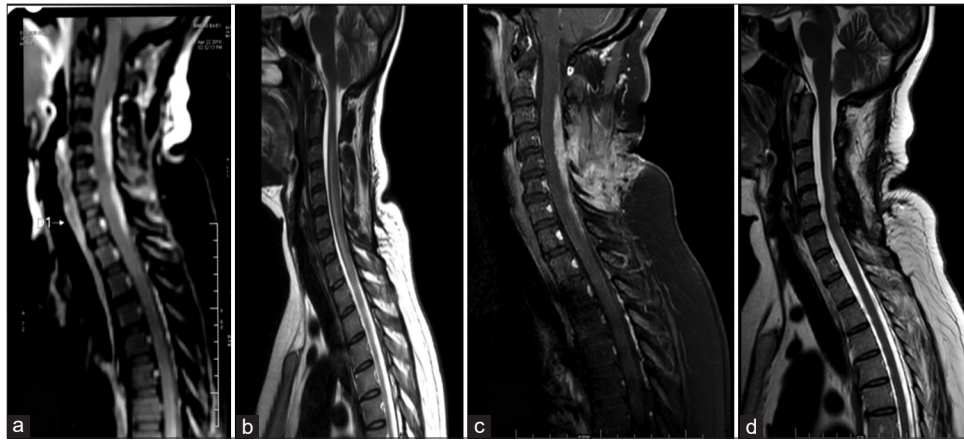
(a) Magnetic resonance imaging (MRI) at presentation; (b) MRI after 1 week of steroid therapy; (c) MRI post-biopsy; (d) MRI – 6-month post-treatment
